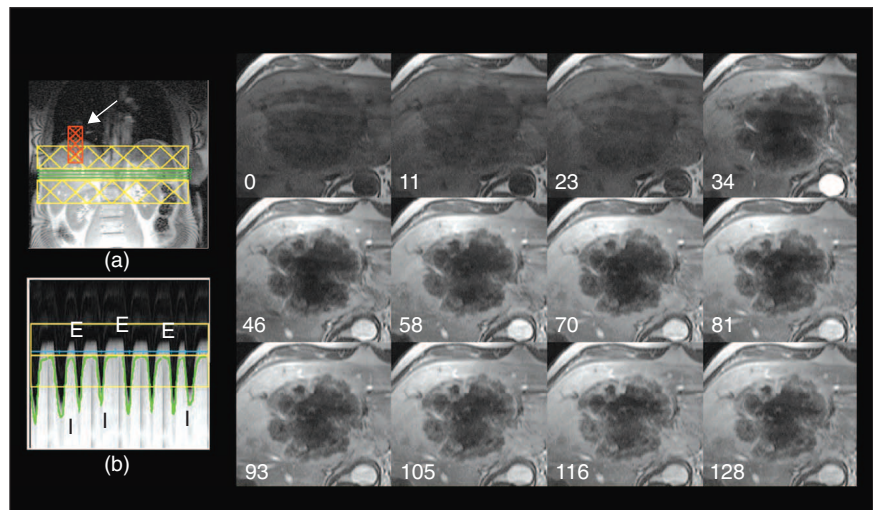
Navigator-guided T1-weighted DCE-MRI of liver metastases. A navigator gradient-recalled echo (GRE) sequence was used for DCE-MRI of liver metastases. a) Scout view showing slice positions, saturation bands, and navigator band (arrowed) at the interface between lung and liver. b) Corresponding navigator trace over a period of 90s. Some inhales (I) and exhales (E) are marked. The collage shows magnified images of one of three image slices from the injection through to +128 s. There was very little motion artefact from chest wall motion. Some motion blurring of the left hepatic lobe was seen due to transmitted cardiac pulsations.
